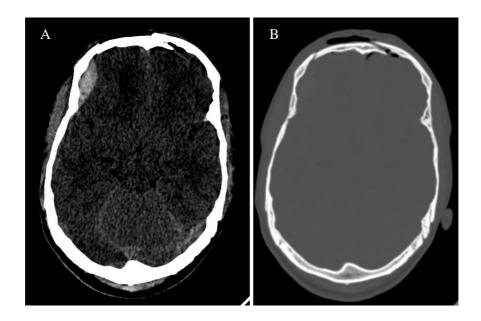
CT Brain plain study in a 31 years old male patient with history of Road traffic accident showing Extradural haemorrhage in right frontal region (A) and fracture of right frontal bone (B)
